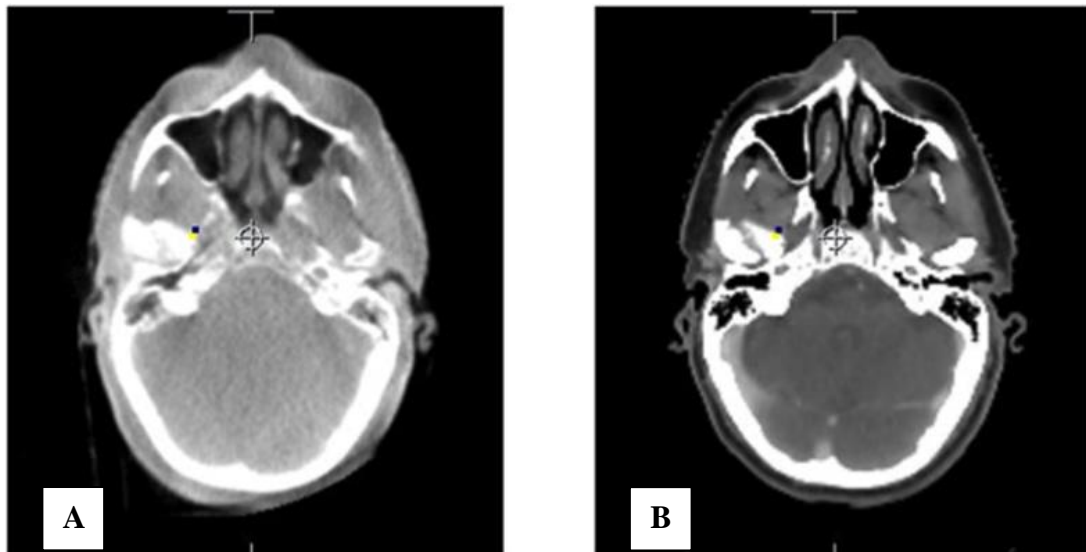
A. Cone beam CT vs. B. fan beam CT (right) of head and neck IGRT in axial and sagittal orientation (Lechuga et. al., 2016)
